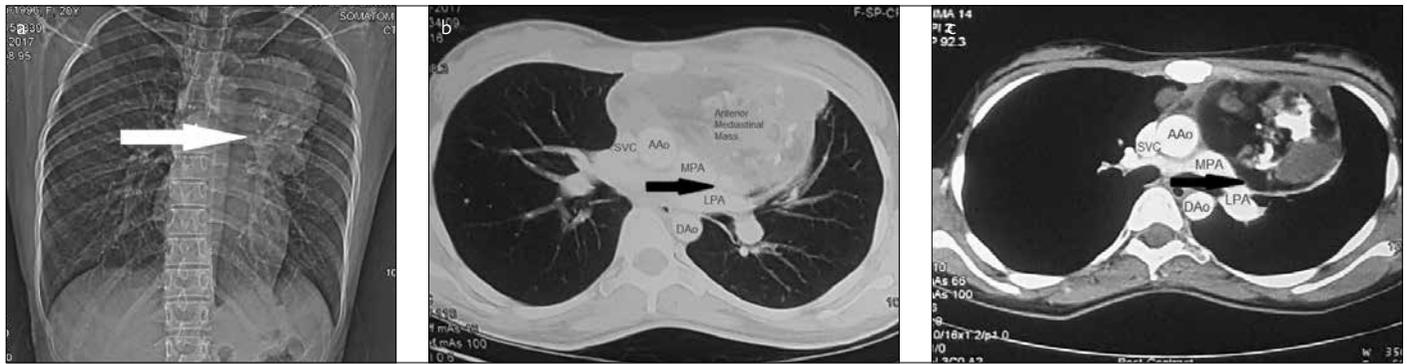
a-c. Coronal view of thorax on CT scan showing anterior mediastinal mass in the left upper thorax (green arrow) (a), Lung window view showing anterior mediastinal mass compressing over the pulmonary artery (green arrow) (b), Mediastinal window view showing anterior mediastinal mass compressing the pulmonary artery (green arrow) (c)
